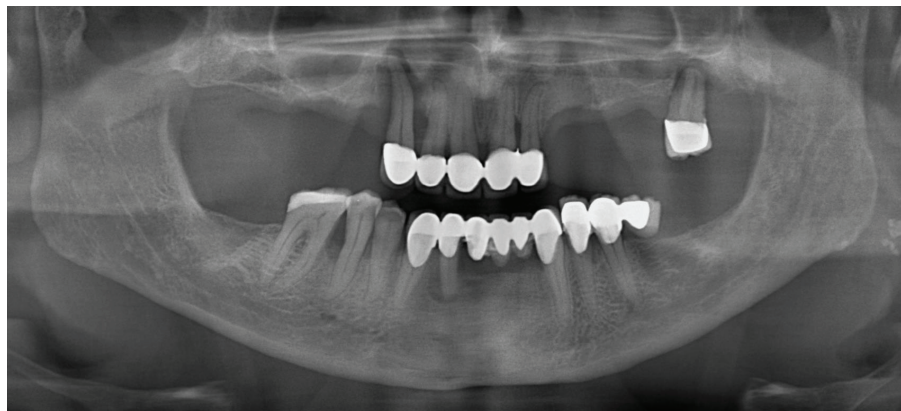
Representative pre-operative orthopantomography of a patient.
